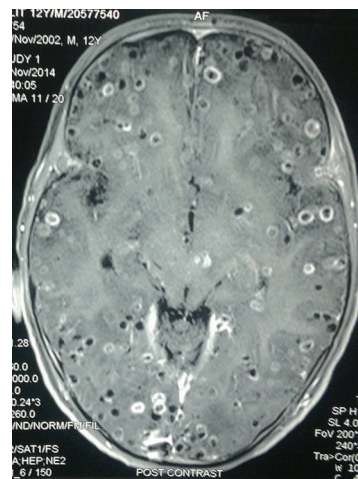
MRI brain showing multiple ring enhancing lesion with eccentric mural nodule in few of them
